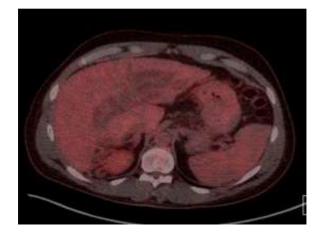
PETCT axial image at the level of the liver reveals physiologic FDG uptake.
